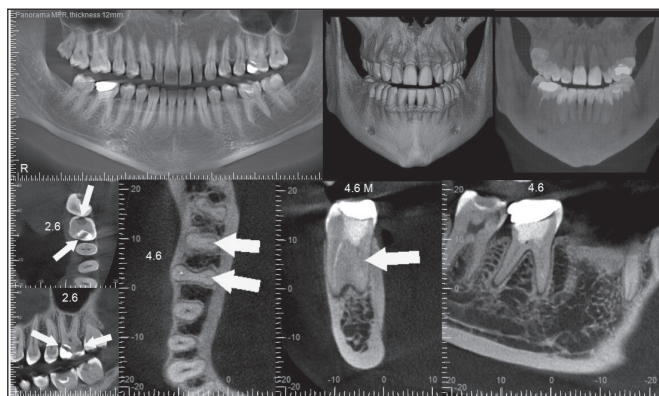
OPG and CBCT screenshots of a patient P. Hidden carious cavities in teeth 2.6 (K4), 4.7 (K5)
